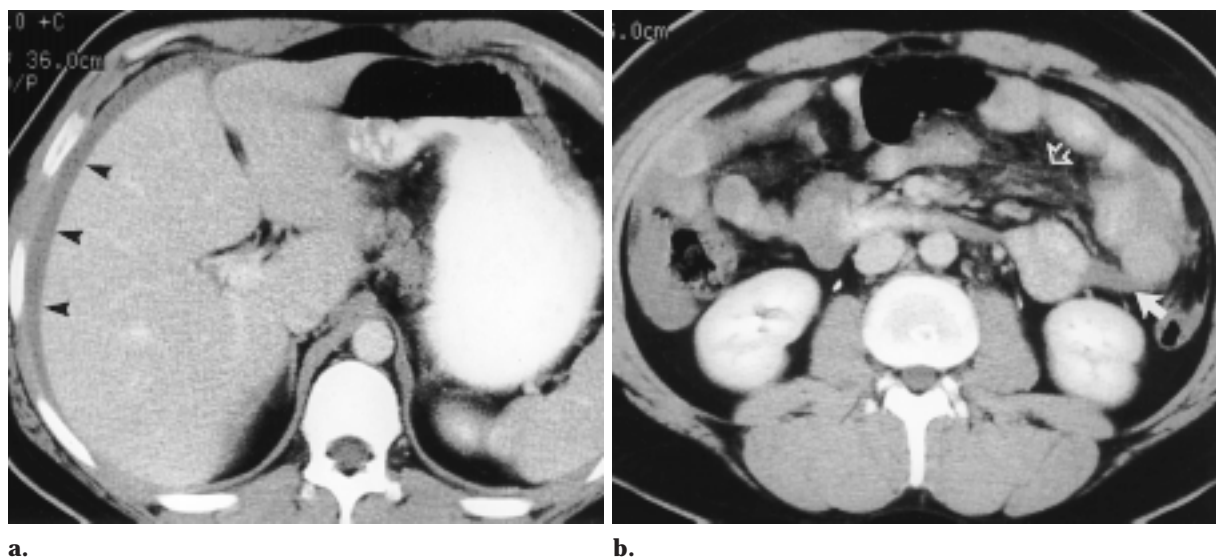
Midjejunal partial thickness tear but normal liver and spleen in a 20-year-old man. (a) Abdominal CT scan shows hemoperitoneum surrounding the intact liver capsule (arrowheads). (b) CT scan obtained at a lower level reveals interloop fluid (solid arrow) and mesenteric stranding (open arrow) in the absence of bowel-wall thickening, findings that are more suggestive of mesenteric injury than of parenchymal organ damage.
